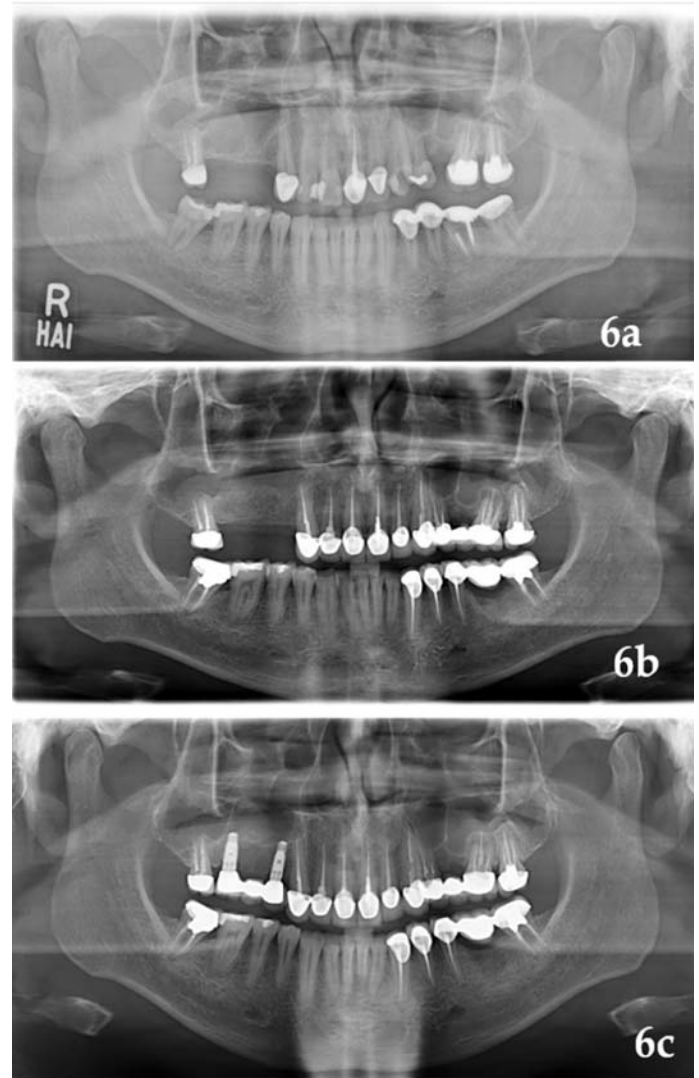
Panoramic radiographs. (a) Preoperative, (b) Before implant placement, (c) 18 month follow up.
